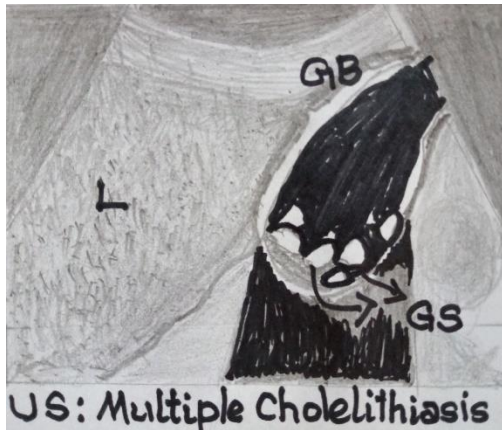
Ultrasound image shows multiple hyperechoic stones (arrow) in the lumen of the gallbladder (Labelled) with obvious posterior acoustic shadowing
